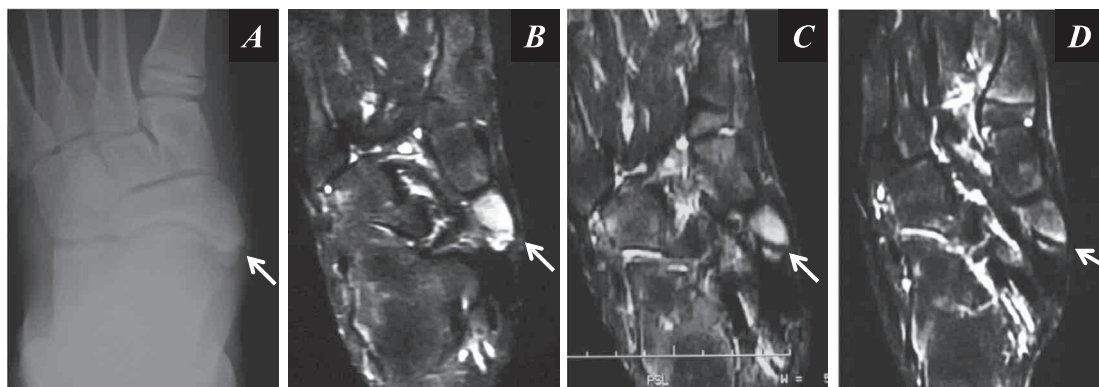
For case 3, type II accessory navicular bone on radiograph (A). T2-weighted fat saturated MR image demonstrates the same pattern as the case 1 at the first examination (B). The edema-like bone marrow pattern gradually diminishes with alleviation of the symptom a month (C) and three months (D) after the first presentation.
